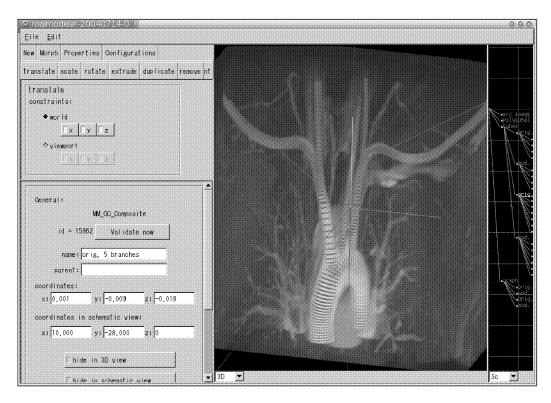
A 3D volumetric representation of human aorta rendered using a set of MRI slices of images.
